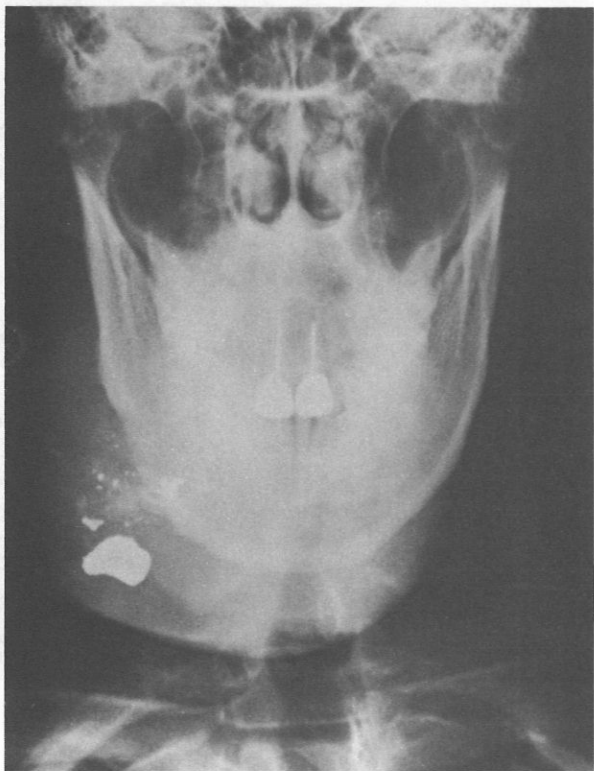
Anterior-posterior radiograph of skull.
